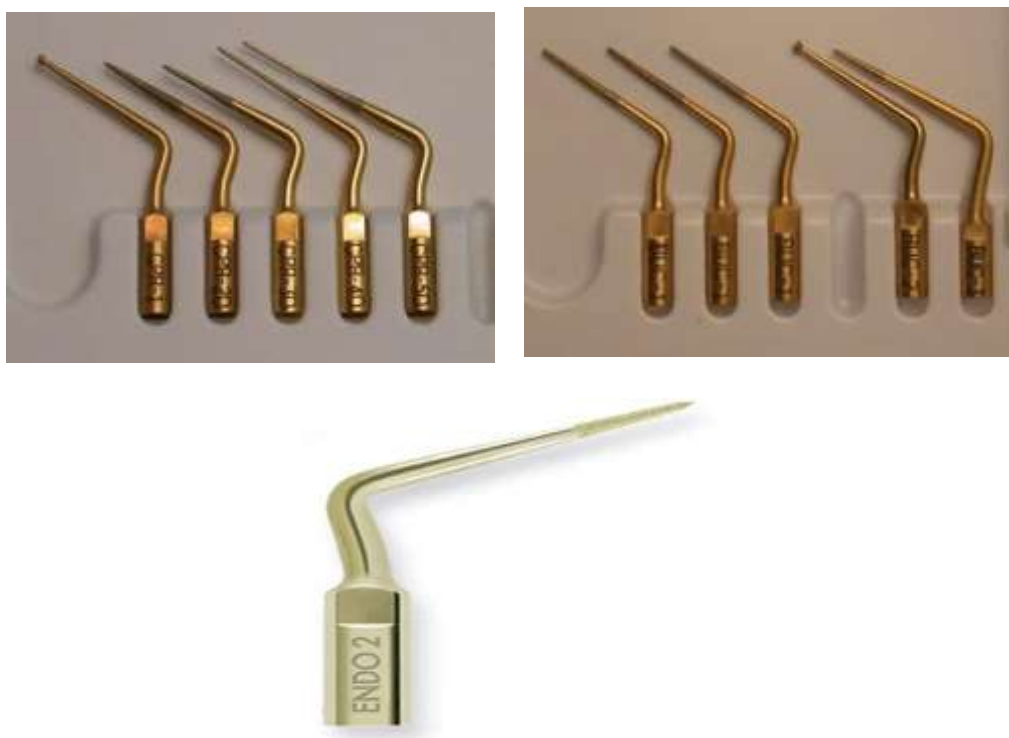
Ultrasonic tips
